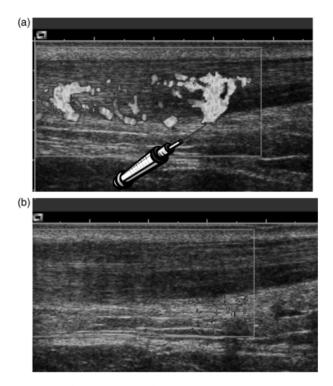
(a, b) Sclerosing injection. Gray-scale ultrasonography and color doppler examination (a longitudinal view) of an Achilles tendon with tendinosis located at the 2–6 cm level in the tendon. The affected area of the tendon is thick, irregular and echo poor. There is a neovascularization outside and inside the ventral part of the area with tendon changes. (a) Before injection of the sclerosing substance. Note the position of the needle close to the neovessels outside the anterior part of the tendon. (b) After injection. Note that there are no remaining neovessels.
